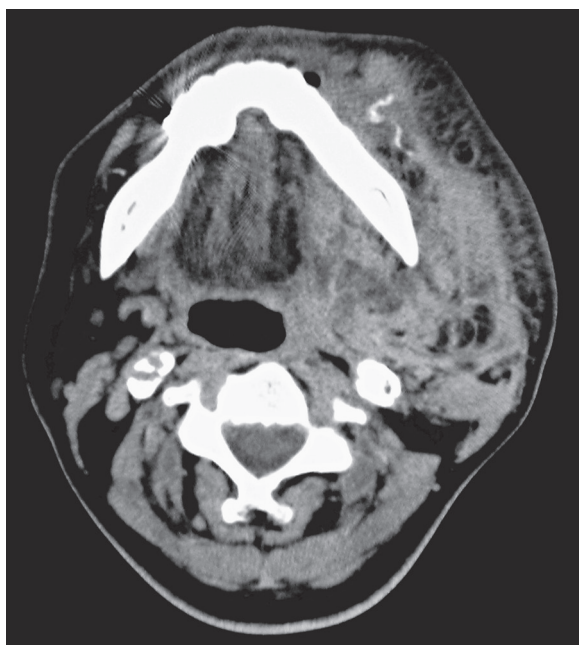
Non-contrast computed tomography, showing a large subcutaneous hematoma of the left cervical region and tracheal displacement to the right.
